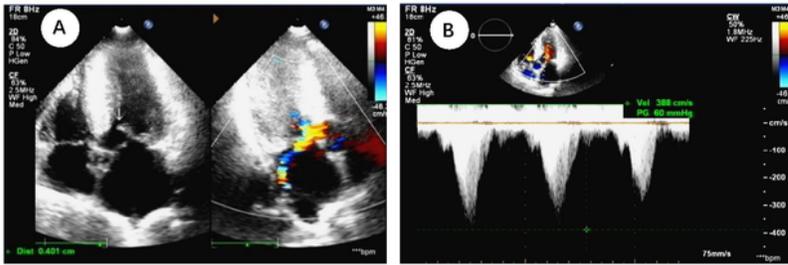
A: four-chamber view with SAM positive and mitral regurgitation. B: Gradients in the left ventricular outflow tract (CW-Doppler) at rest before ERASH, 60 mmHg.
